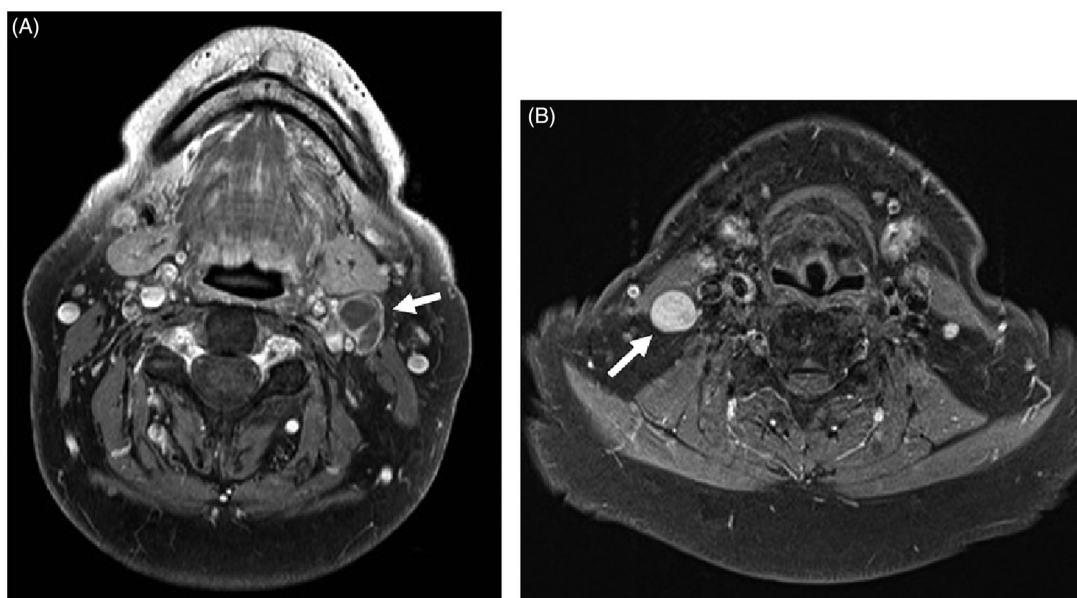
Axial T1-weighted, fat-suppressed contrast-enhanced MR images. (A) The presence of central necrosis in level II lymph node (arrow in A) was considered a definitive sign of malignancy. (B) A markedly enlarged and rounded level III lymph node (arrow in B). By size criteria, this node was considered malignant in OTSCC patient. MR: magnetic resonance; OTSCC: oral tongue squamous cell carcinoma.
